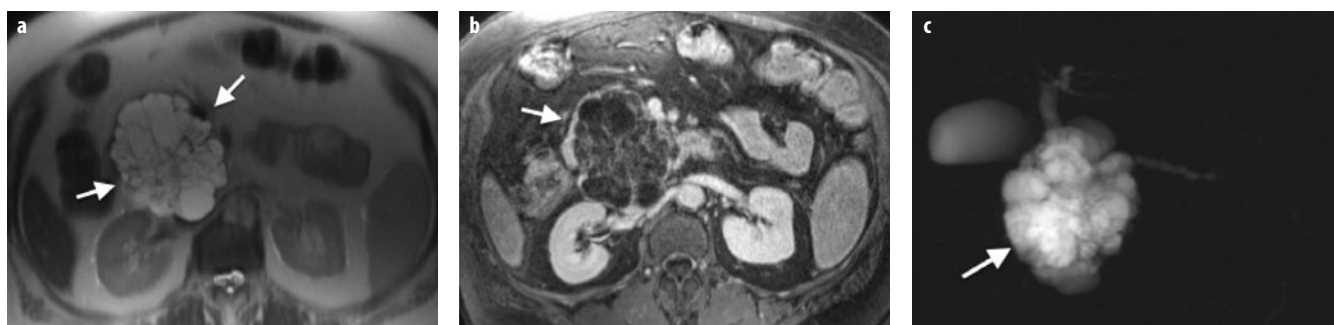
a-c. Serous cystadenoma. a Axial T2-weighted turbo spin-echo image (TR/TE 4,500/102) shows a multicystic microcystic neoplasm of the head of the pancreas (*arrows*). b On axial fat-saturated volumetric T1-weighted gradient echo image (TR/TE 4.86/1.87 ms) during the portal-venous phase of the dynamic study following gadolinium-chelate administration, serous cystadenoma shows enhancement of the internal septa and lack of a peripheral wall. c On coronal magnetic resonance cholangiopancreatography (MRCP) single-shot rapid acquisition with relaxation enhancement (RARE) (TR/TE \times /110 ms), serous cystadenoma (*arrow*) is responsible of compression of the main pancreatic duct with upstream dilatation
